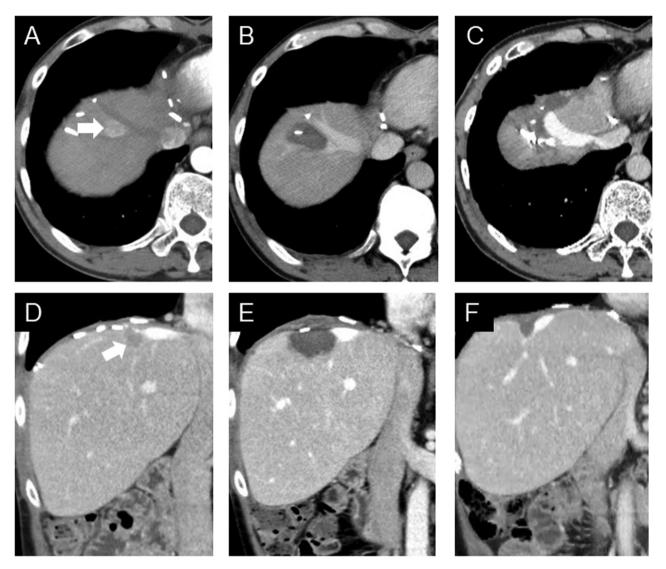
Contrast-enhanced computed tomography (CT) before and after radiofrequency ablation. Axicial CT (A-C) and Coronal CT (D-F). Before ablation (A, D), I week after the first ablation (B, E), 3 months after open ablation (C, F). A viable lesion was found between the right hepatic vein and V7 at the time of initial recurrence (A, D). After the percutaneous radiofrequency ablation, the ablation margin was insufficient (B, E). Complete ablation was achieved after open radiofrequency ablation (C, F).
